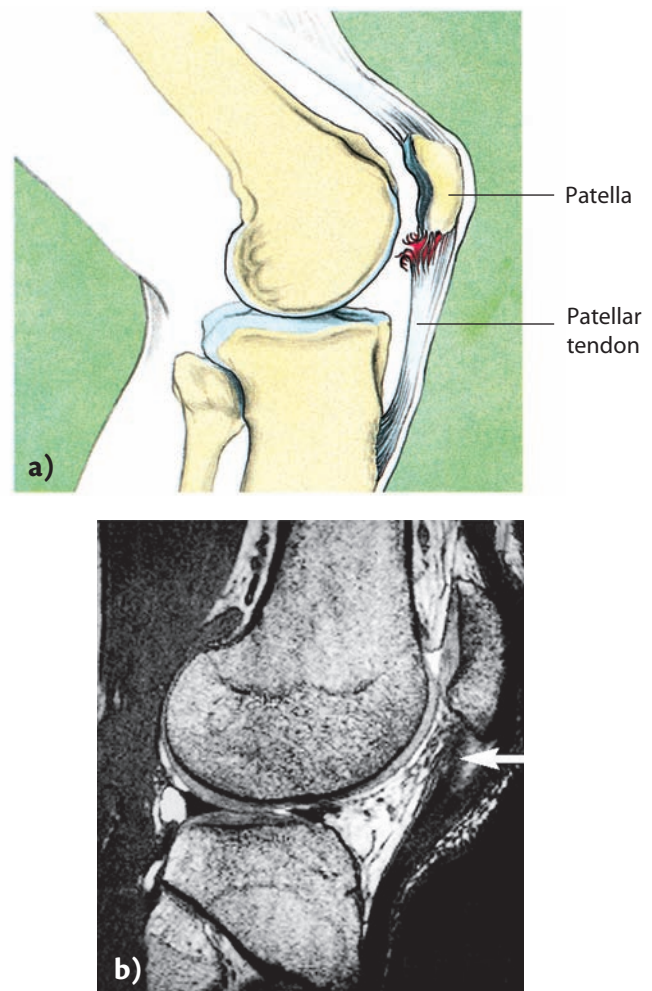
Patellar tendinopathy, overload, of the patellar tendon. a) Damage to the patella tendon's upper posterior portion at the attachment to the patella; b) Magnetic resonance imaging shows the same damage (arrow).
